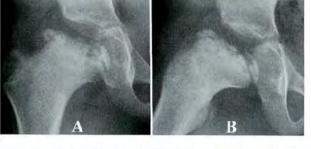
(A) AP and (B) frog leg lateral radiographs of the hip in a 9 year old girl with pillar C type LCP disease.
